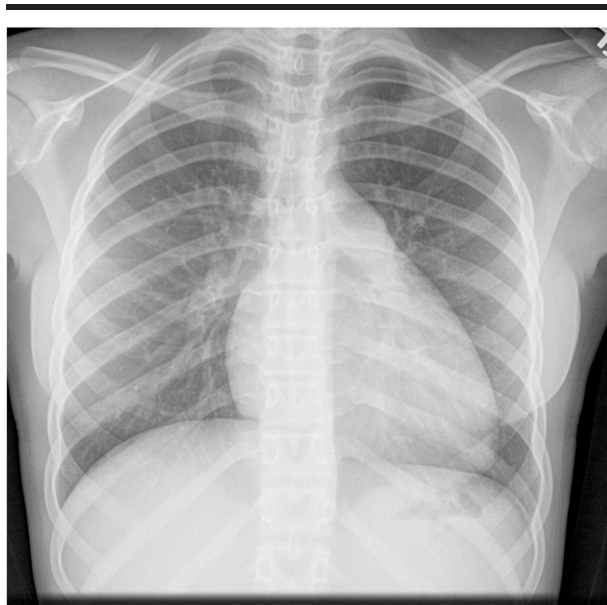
Chest x-ray with borderline cardiomegaly, poorly vascularized lungs, a prominent pulmonary artery, and a pronounced right heart border.
